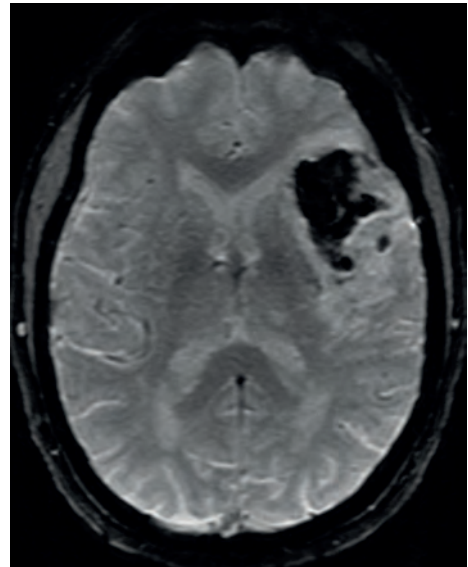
T2-weighted image of hemorrhagic infarction type 2*
